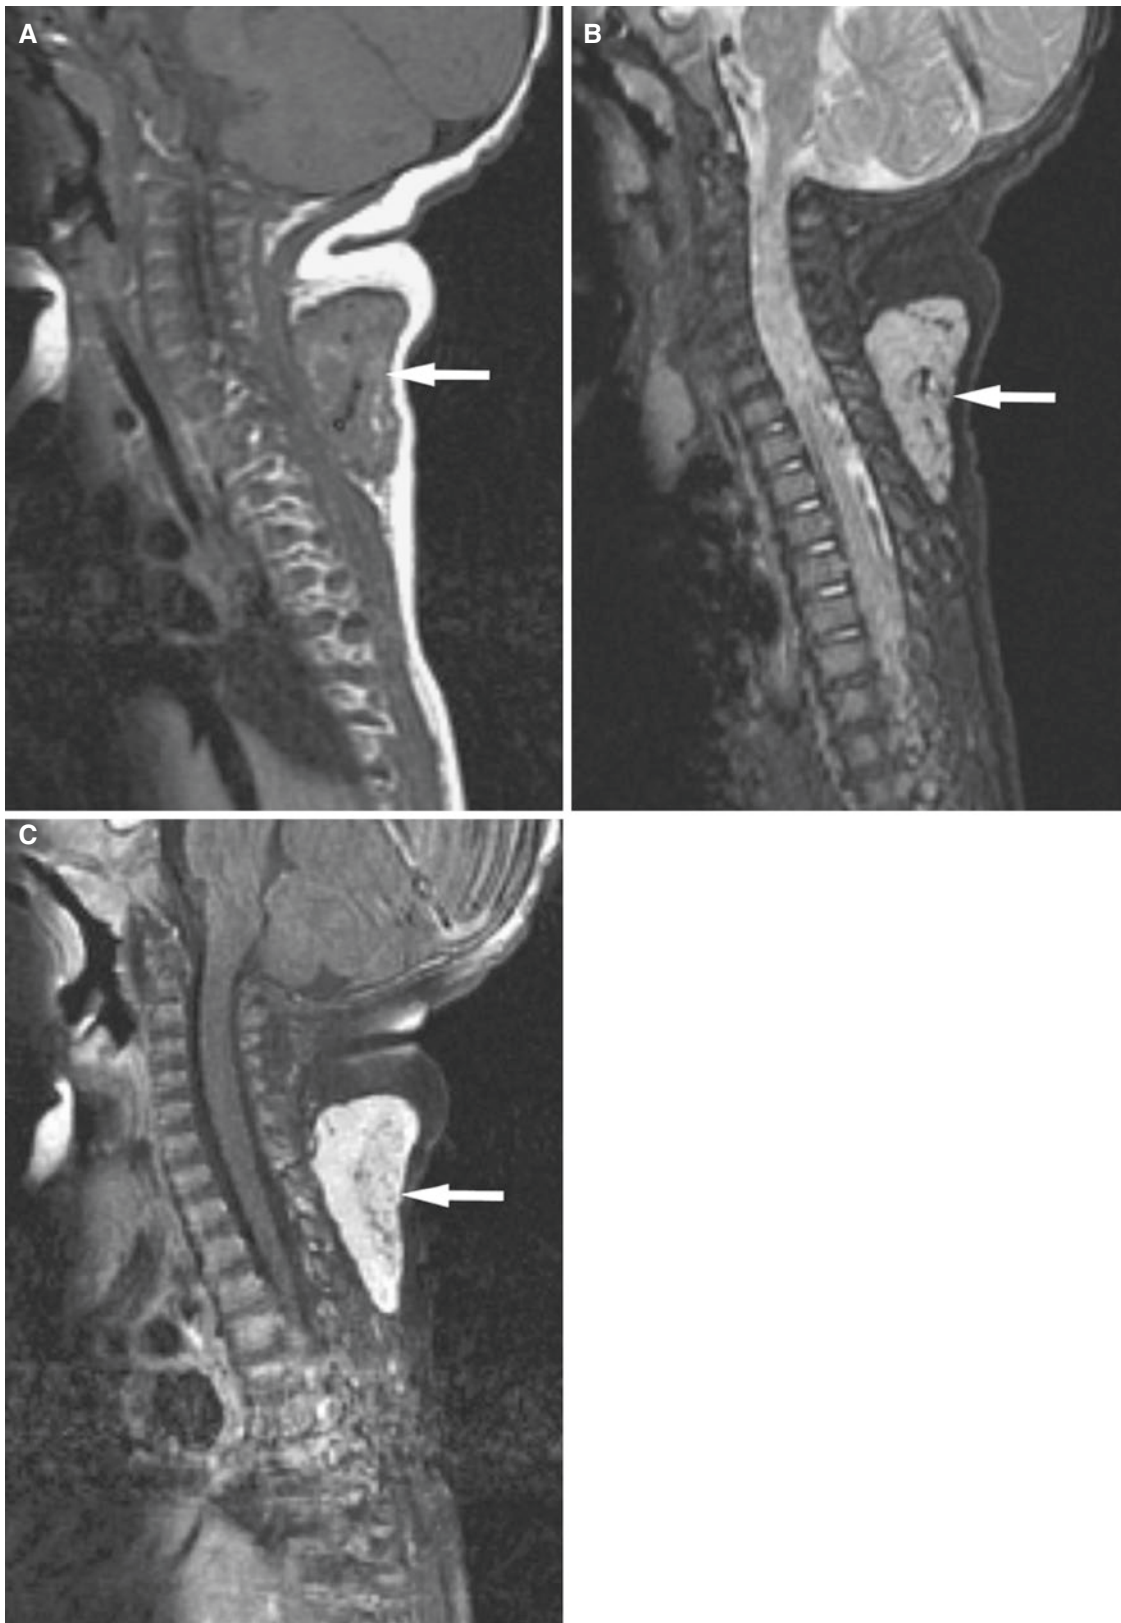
Hemangioma; 6-month-old infant twin girl presents with mass in back of neck. The mass has been observed for only a few days. (A) Sagittal T1-weighted MRI shows a well-circumscribed large mass in posterior neck with flow voids (*arrow*). (B) Sagittal STIR MRI shows
